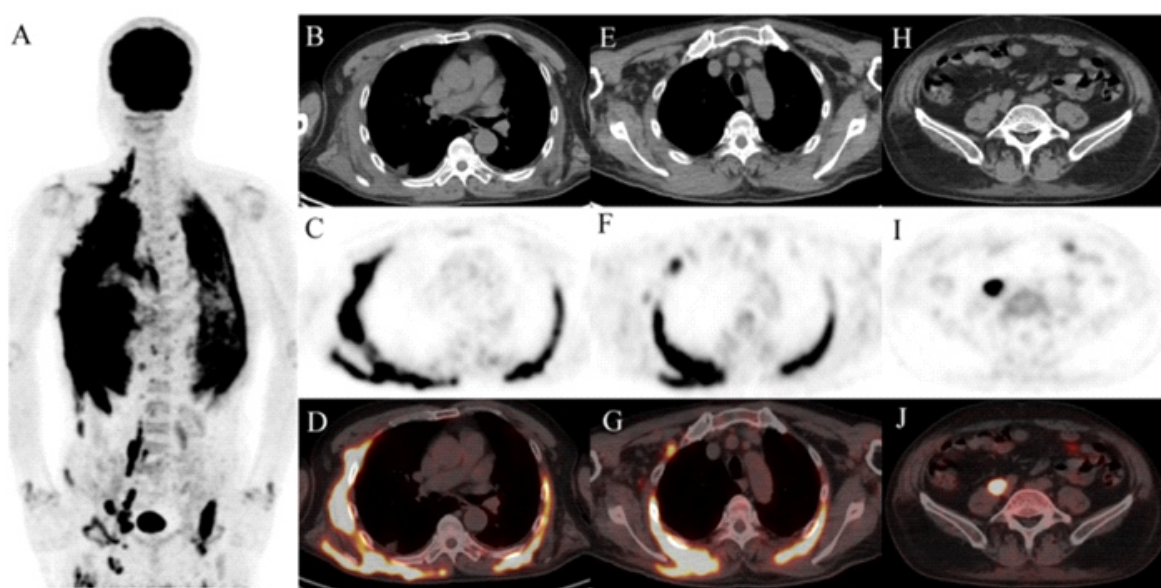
A 66-year-old male presented with sudden onset dizziness and headache, persisting for three days without any apparent triggers. His medical history included chronic atrophic gastritis and duodenitis diagnosed via gastroscopy. A chest CT scan revealed enlarged lymph nodes in the right axillary region and heterogeneous thickening of the right chest wall soft tissue. To further delineate the nature and extent of the lesions, ¹⁸F-FDG PET/CT imaging was performed. The imaging revealed thickening and edema in the soft tissues and muscles of bilateral chest walls, abdominal walls, back, right pelvic wall, right neck, and upper parts of both thighs, with band-like and nodular increased radiotracer uptake (A-D, SUVmax 18.0). Multiple metabolically active lymph nodes were observed in various regions including the right supraclavicular area, right axilla (E-G, SUVmax 5.9), mediastinum stations 6 and 8L, right internal mammary area, bilateral paraaortic feet, retroperitoneum (H-J, SUVmax 15.6), bilateral iliac vessels, and right inguinal area. Laboratory tests indicated elevated γ -glutamyltranspeptidase levels at 95U/L (normal range 10-60U/L), an unspecified enzyme level significantly increased to 317U/L (normal range 109-245U/L). The patient had anti-SSA-60 antibody levels of 2.14 (normal range 0-1) and anti-Jo-1 antibody levels of 8.30 (normal range 0-1).
